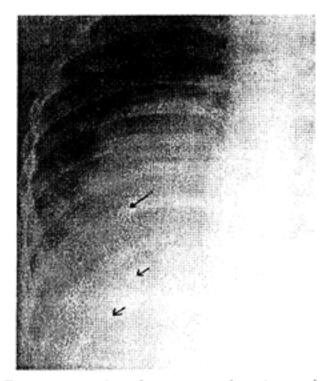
Postero-anterior chest x-ray showing soft tissue mass with a few calcific foci (arrows) in right hemithorax.
